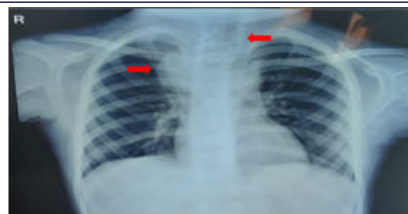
chest x-ray shows right hilar convexity with tracheal shift to left
